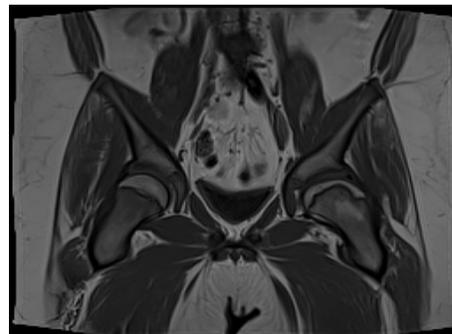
Perthes disease, MRI
